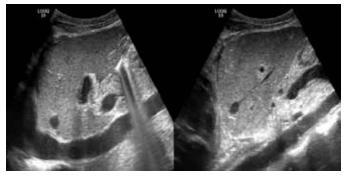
Abdominal ultrasound identified moderate ascites with a normal-sized homogeneous texture liver.
